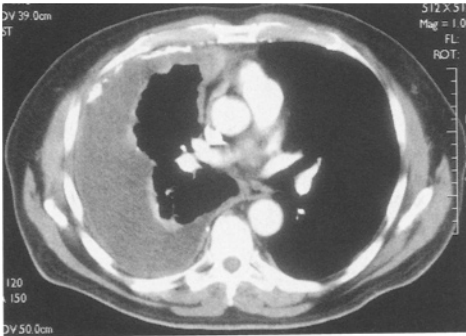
CT scan: 72 year old man with epithelioid mesothelioma. There is a large right pleural effusion with thickening of both visceral and parietal pleura with areas of calcification due to engulfment of pre-existing benign plaques
